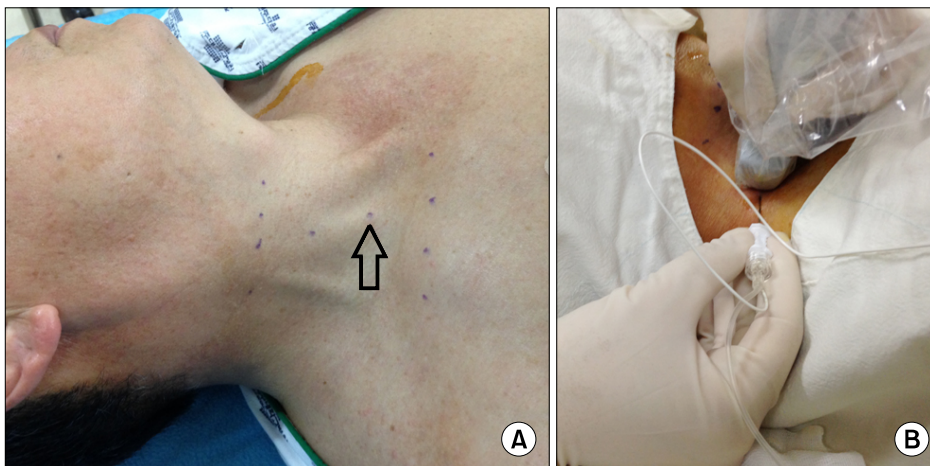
Anatomical landmark (A) and ultrasound probe and block needle position during ultrasound-guided low approach interscalene brachial plexus block (B).
